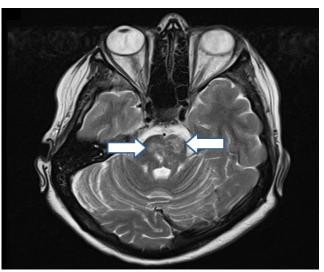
T2 – FLAIR MRI – Subacute median and left paramedian pontine ischemic stroke
